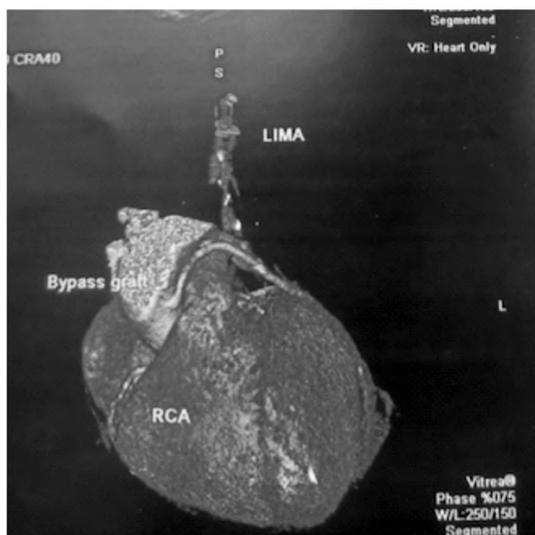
CT coronary angiography showing totally occluded LIMA due to noncompliant patient with anticoagulation.
